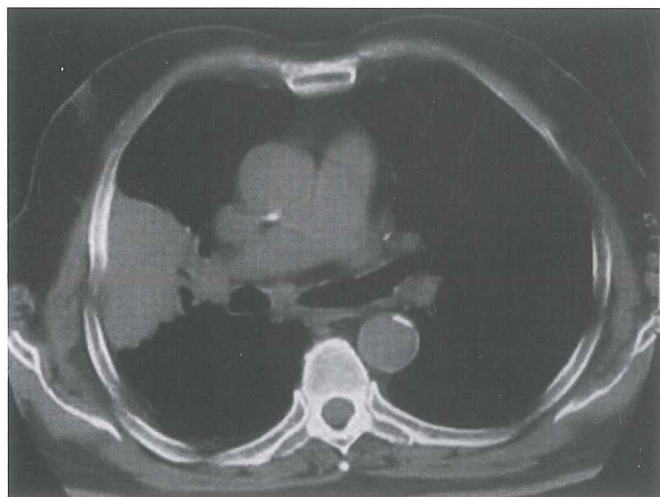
Chest CT scan shows right sided hilar tumor and associated atelectasis. This patient had multi-station N2 disease and was administered neoadjuvant treatment prior to surgical resection.
